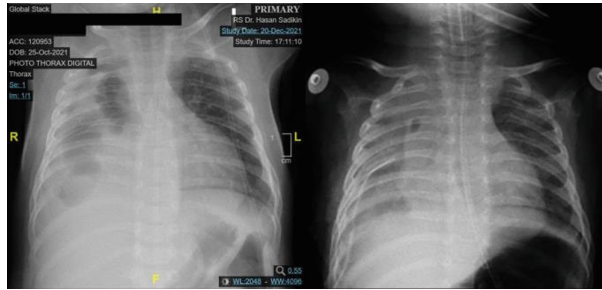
Before surgery (left) and after (right) X-rays shows no contamination or pneumonia afterward at the left lung.
